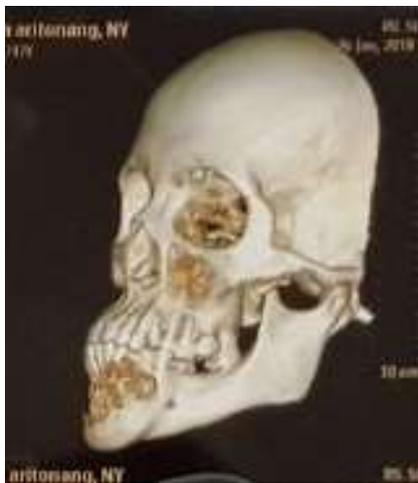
a-c. 3D CT scan
